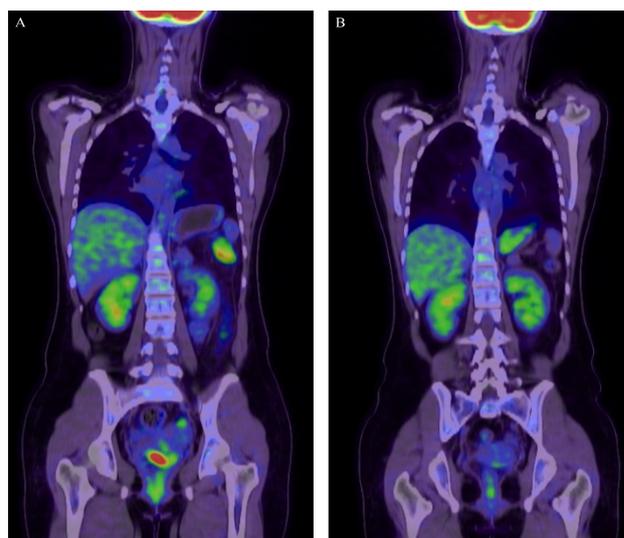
Coronal fused fluorodeoxyglucose (FDG) positron emission tomography (PET)/computed tomography (CT) images. Before (left) and after (right) the NACT showing near complete resolution of the lesion. The focal FDG uptake of uterine cervix significantly decreased in intensity (SUV max: 11.34 → 3.13). The small lymph nodes of the right external iliac chain are indistinct due to a decreased in size.
